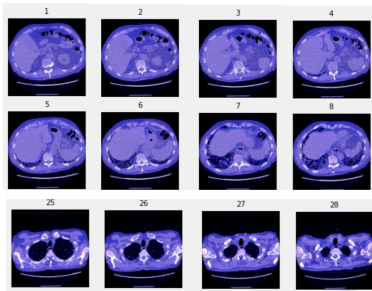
Chest CT-scan from patient ID00007637202177411956430.
